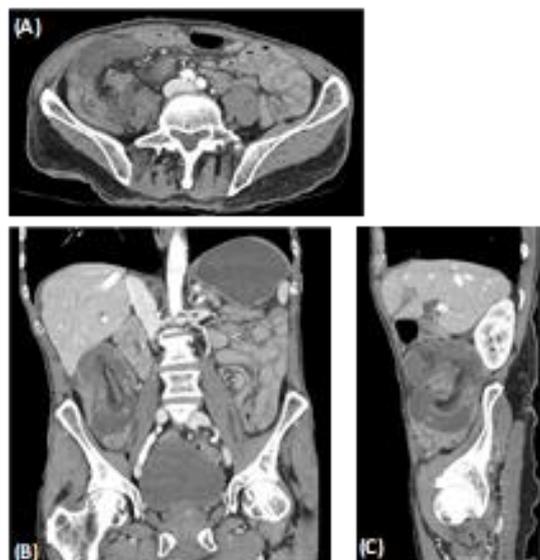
Abdominal computed tomography (CT) scans. A: Axial slide; B: Coronal slide; C: Sagittal slide.
